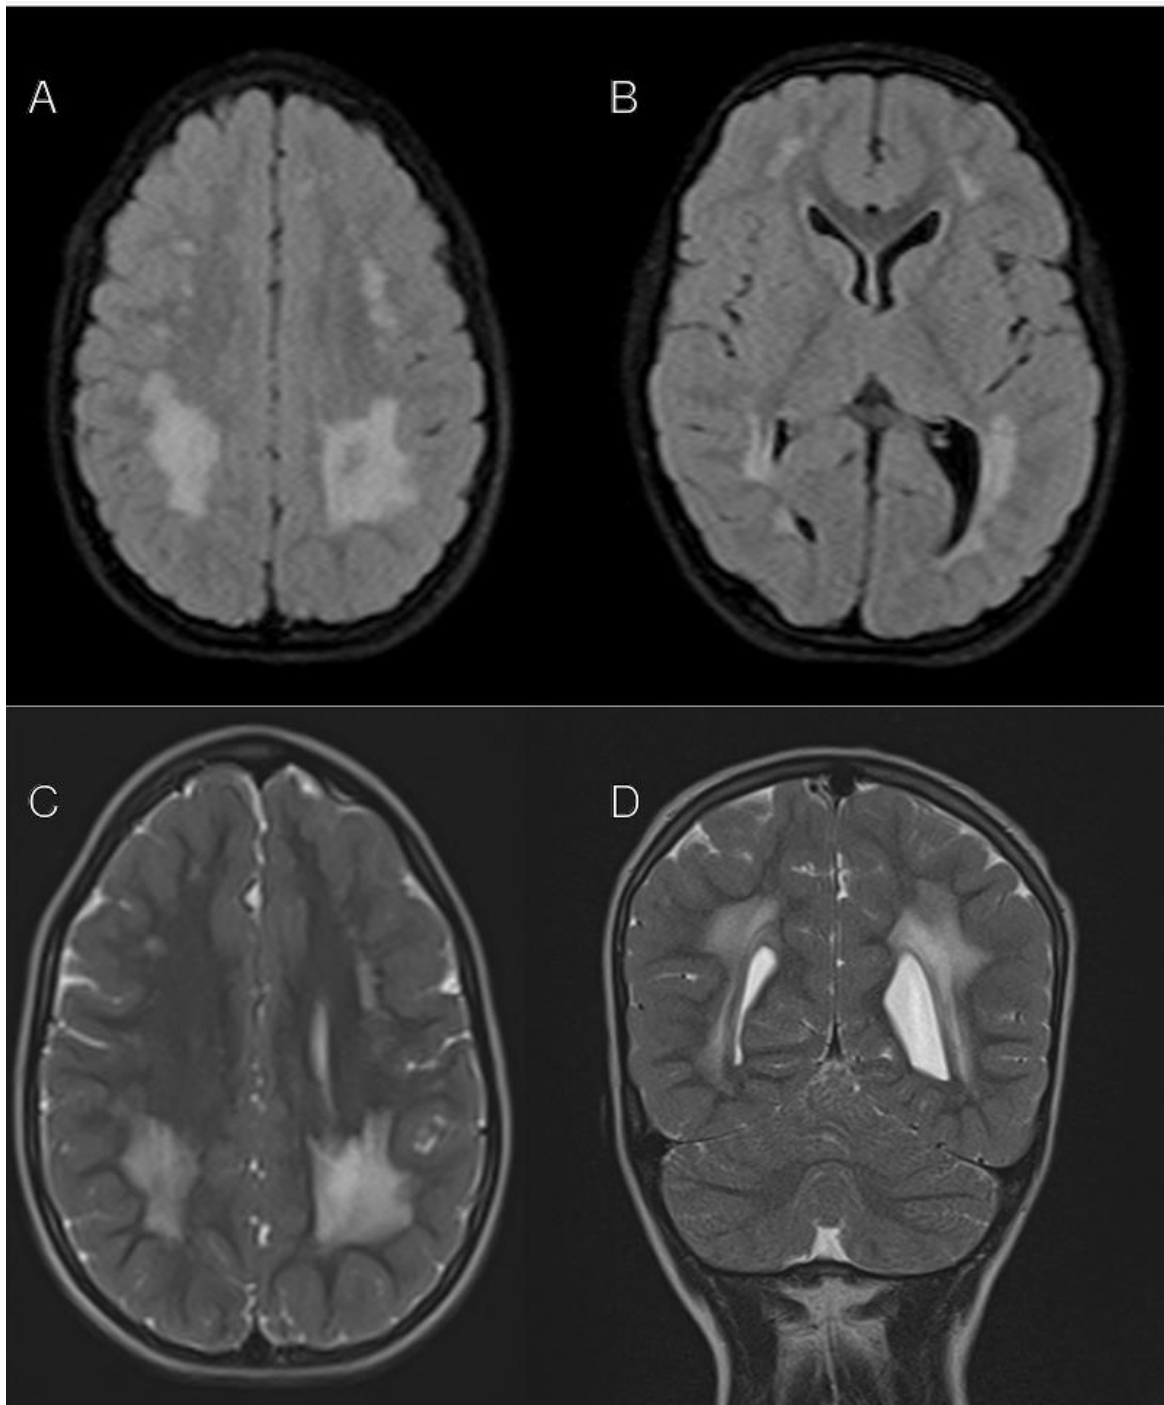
Brain MRI in a 6-year-old girl with developmental regression and seizures. Axial FLAIR images (A, B) and axial (C) and coronal (D) T2-weighted images demonstrate bilateral, symmetric, confluent hyperintensity of the periventricular and deep white matter, with parieto-occipital predominance and frontal extension. The subcortical U-fibers are relatively spared. The deep gray nuclei and corpus callosum are preserved on the displayed images.
